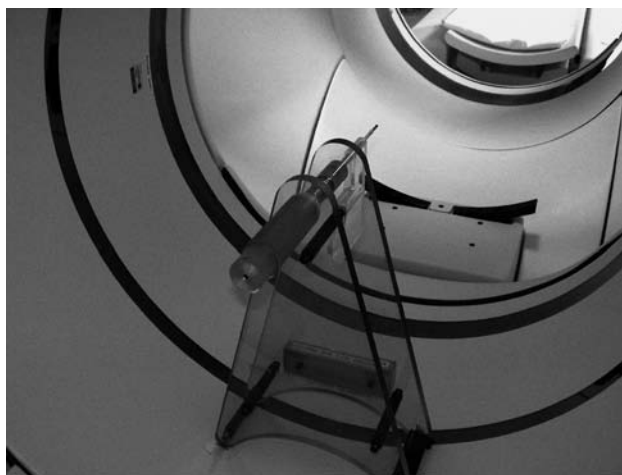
A Philips Gemini TruFlight PET/CT, with a source holder in the position for daily QC; the same acquisition set-up is used to check the photomultipliers and the energy and time resolutions, as well as to acquire a sinogram for visual inspection.
